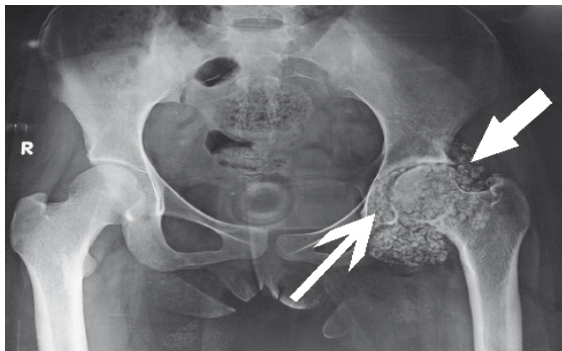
Radiograph of the pelvis shows multiple radio-opaque loose bodies of variable size in the left hip (thick arrow) with widened infero-medial joint space and mild irregularity of left femoral head (thin arrow).
